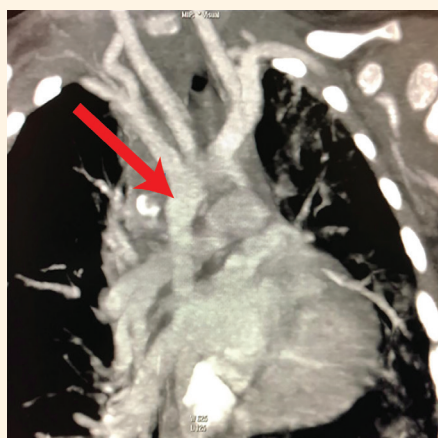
Coronal reformatted computed tomography scan of the lungs of a 16-month-old girl showing right-sided aortic arch (red arrow) with a midline descending aorta.
